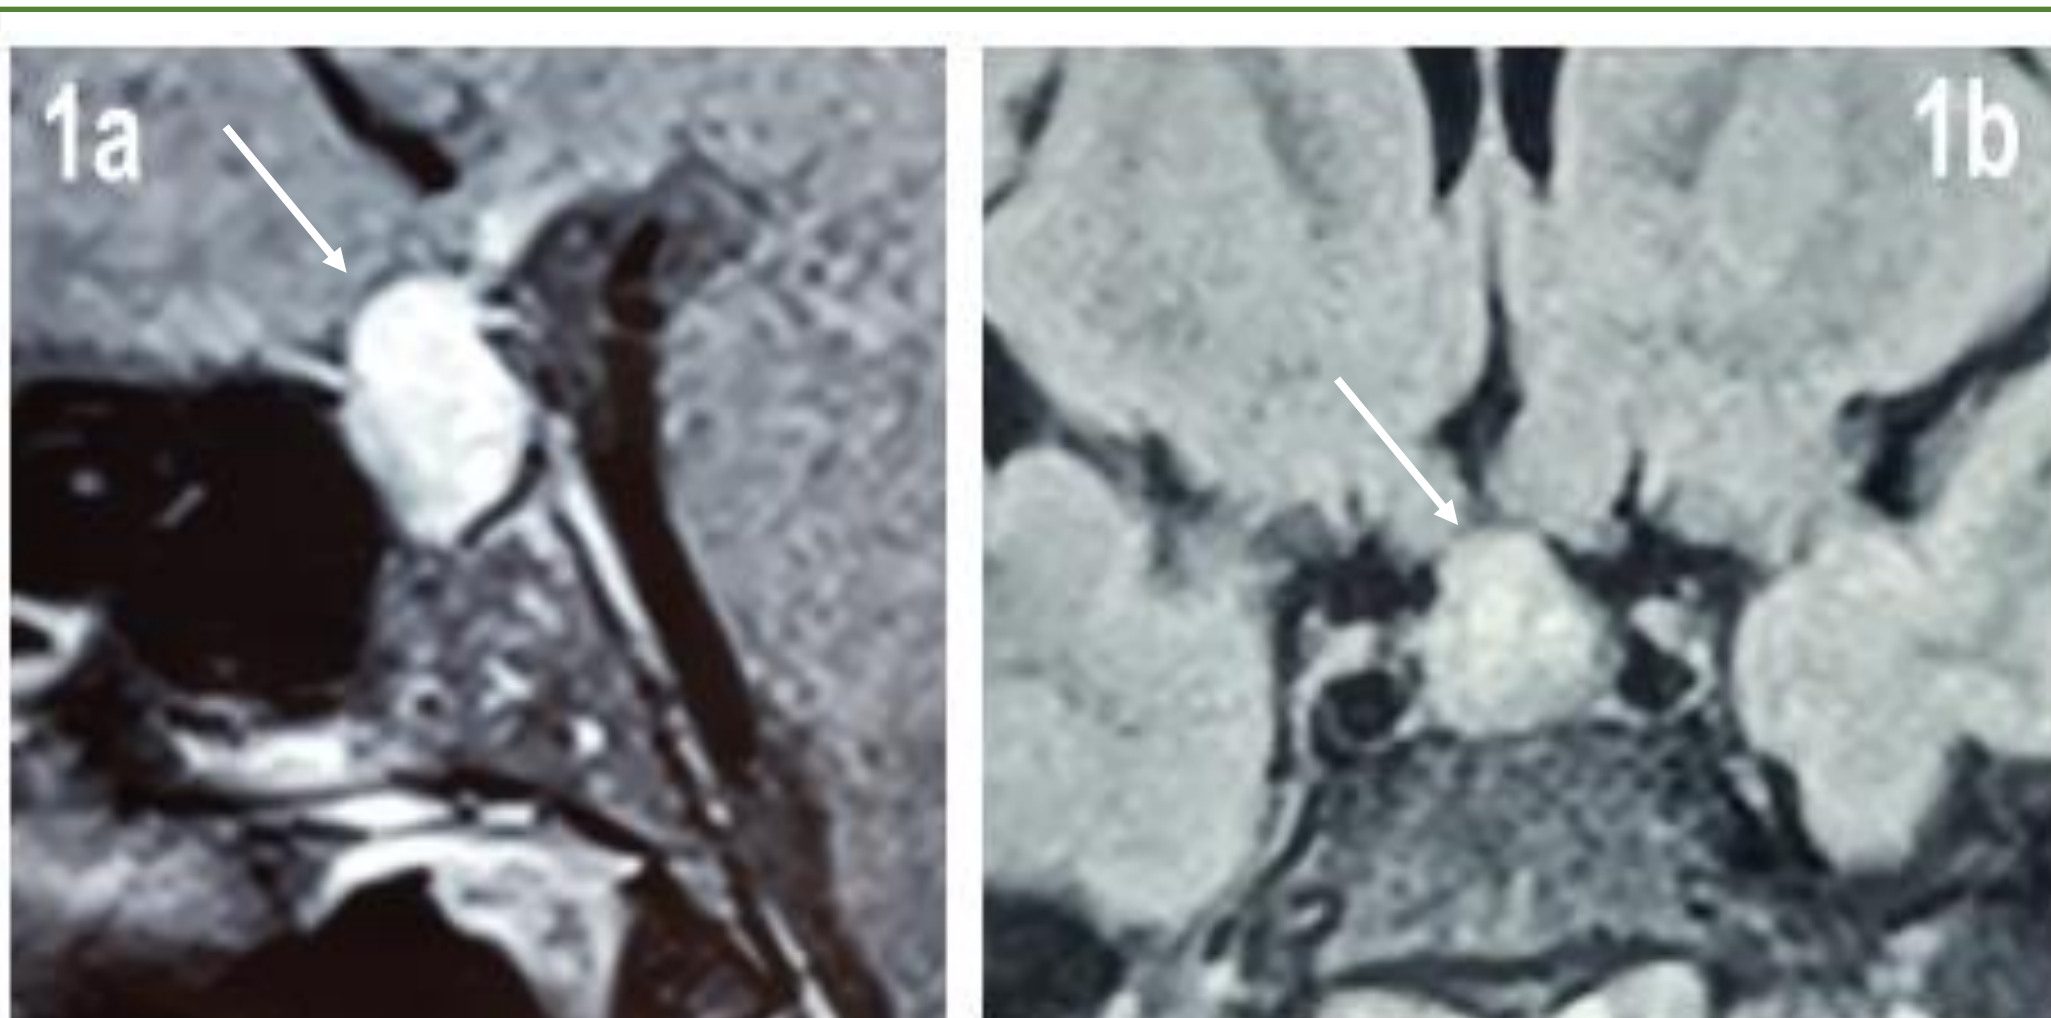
Initial imaging on contrast enhanced sagittal and coronal MRI
